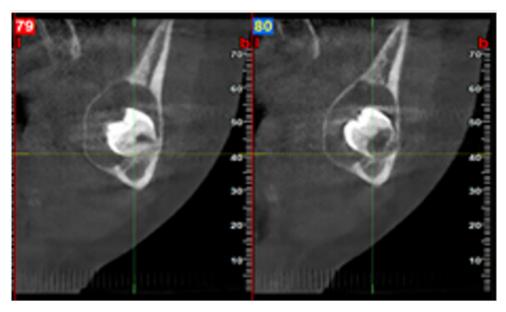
Preoperative computed tomography examination showing large, circular, well-defined uniocular areas covering the crowns of mandibular left and right third molars.
